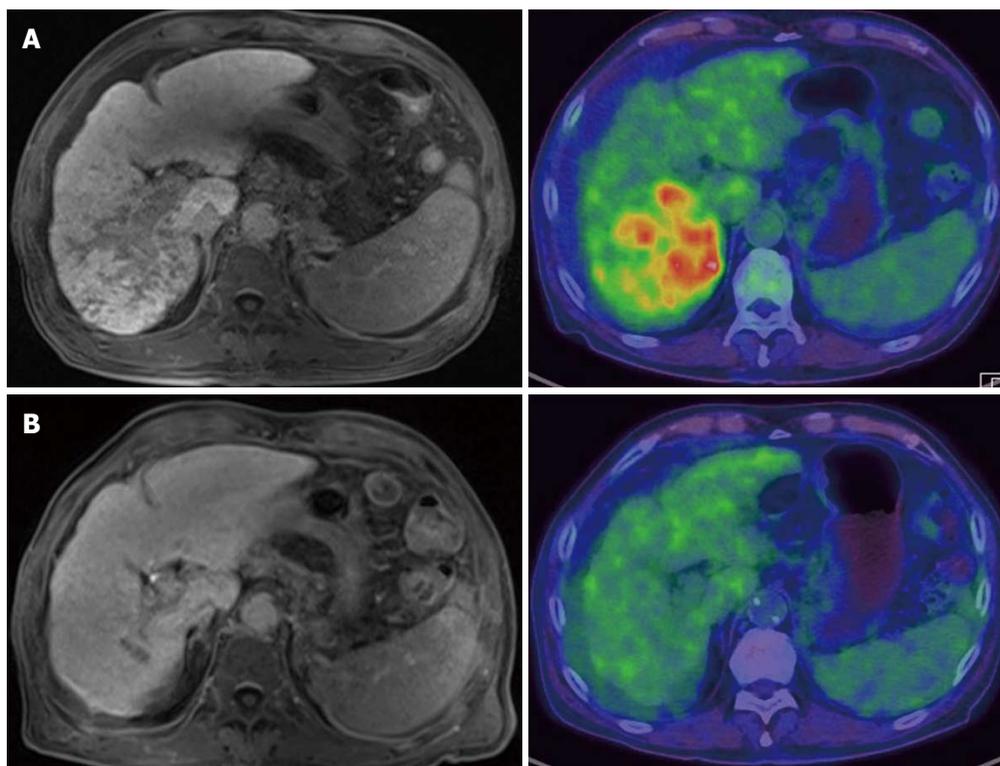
Favorable outcome of patient with infiltrative hepatocellular carcinoma treated by hepatic artery infusion chemotherapy. A: Patient with infiltrative type hepatocellular carcinoma (HCC) with portal vein thrombosis in liver dynamic magnetic resonance imaging (MRI) showed high FDG uptake; B: After hepatic artery infusion chemotherapy, this patient showed no viable HCC except focal portal vein thrombosis in a follow-up liver MRI and positron emission tomography/computed tomography.
